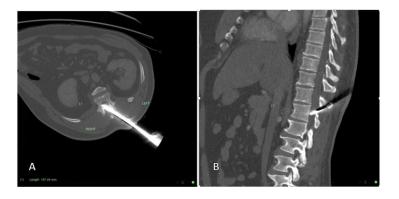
CT of a non-missile penetrating injury
